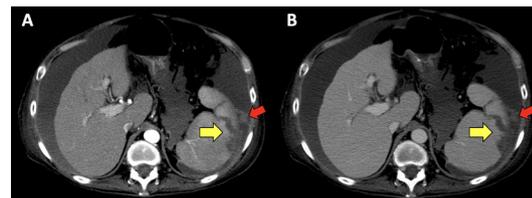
Contrast-enhanced CT scan of the abdomen performed in the arterial phase (A) and portovenous phase (B) demonstrating the presence of haemoperitoneum (red arrows) and persistence of irregular, linear-branching hypodensities (yellow arrows) that traverse across the entire thickness of the enlarged spleen. No active contrast extravasation is seen. In this setting of spontaneous acute abdominal pain without prior abdominal injury, CT features were compatible with non-traumatic rupture of the spleen.
